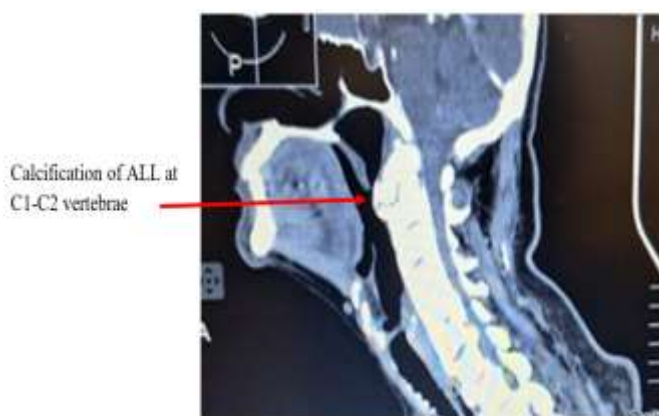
Cervical computed tomography (CT) scan showing calcification at anterior aspect of C1-C2 vertebrae (arrow)
